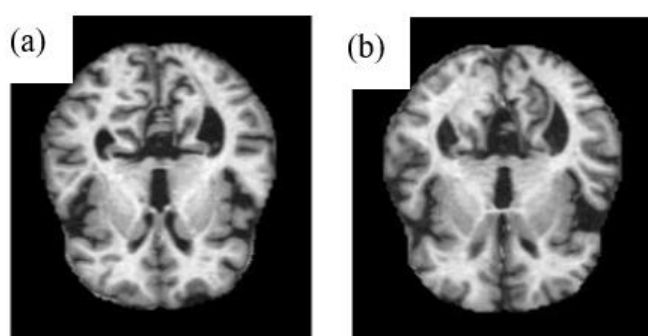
MRI images of (a) the brain of a healthy person (b) the brain of a person suffering from dementia.
